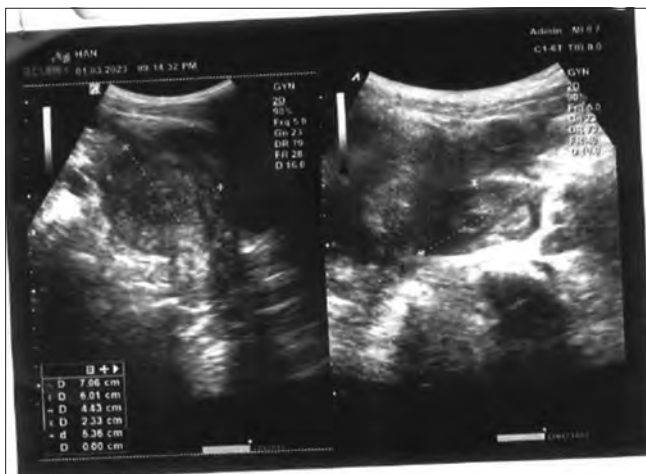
Transvaginal ultrasound scan showing right complex adnexa mass
